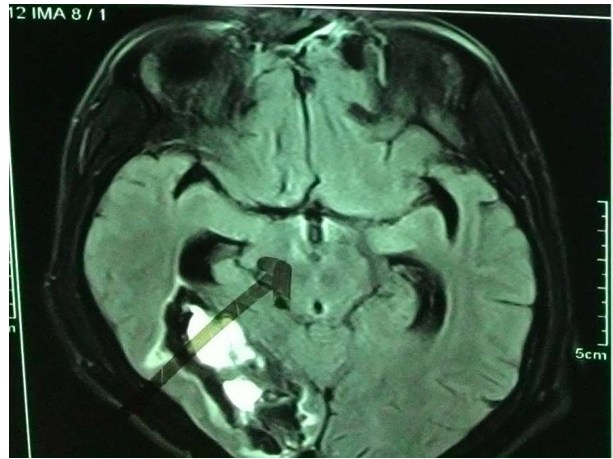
Axial Section of MRI Brain Revealed Flair Hyper Intensity at Site of the Emergence of the Right Cranial Nerve from Medial Aspect of the Right Midbrain Cerebral Peduncle
